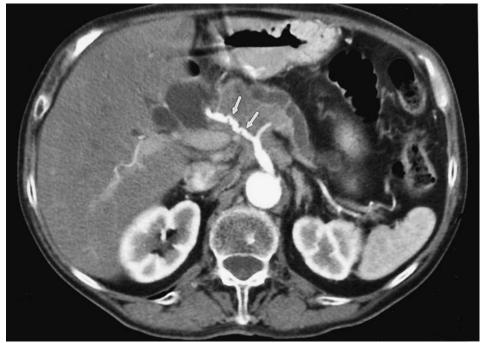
The arterial phase of dynamic CT scan may provide information about hepatic artery invasion (arrows) as well as portal vein involvement. (Courtesy of Henry I. Goldberg, MD.)
